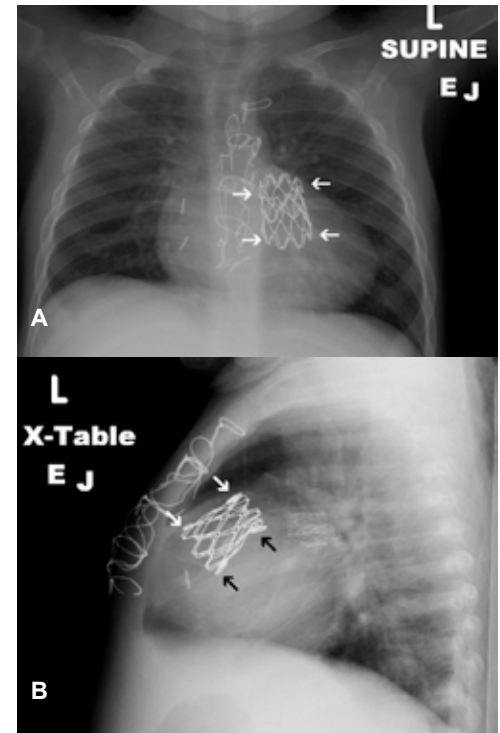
A and B: Chest X-ray obtained following intraoperative Melody Valve™ implantation in antero-posterior (A) and lateral projections (B). Note that the proximal and distal edges of the Melody Valve™ (arrows) have been modified (folded over) to achieve a decrease in length. The branch PA stents are again seen and appear widely patent without fracture.
